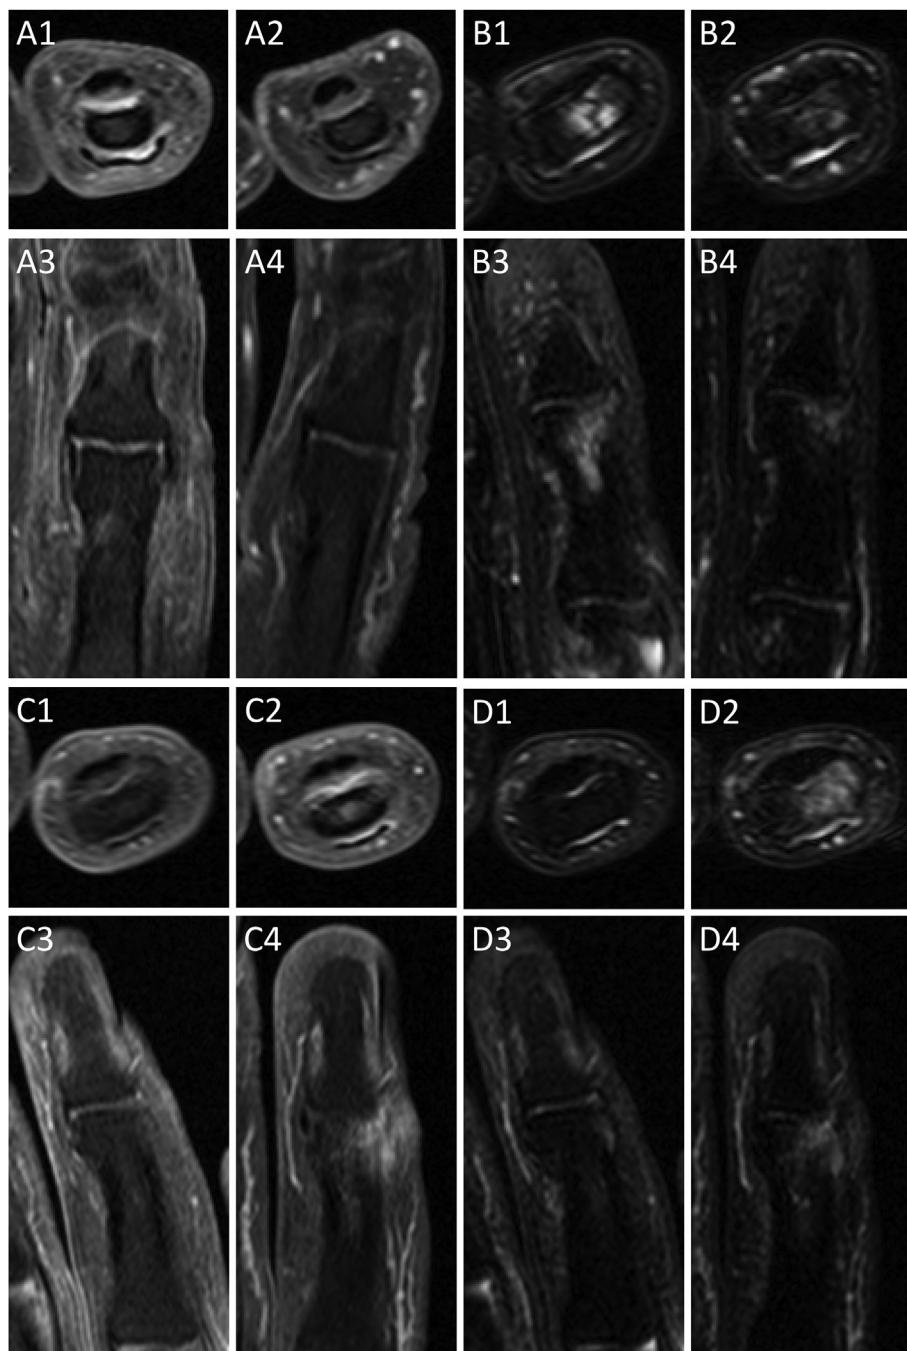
Axial (square panels) and coronal (rectangular panels) fat saturated T1-weighted TSE with post-gadolinium enhancement (A, C) and fat saturated T2-weighted TSE (B, D) MR imaging showing changes in interphalangeal joints between baseline (odd numbers) and follow-up 2 years later (even numbers): decrease in synovitis in a fifth PIP joint (A); decrease in BML in a fifth DIP joint (B); increase in synovitis (C) and BML (D) in the same fourth DIP joint. The center of coronal images corresponds to the level of the axial images.
